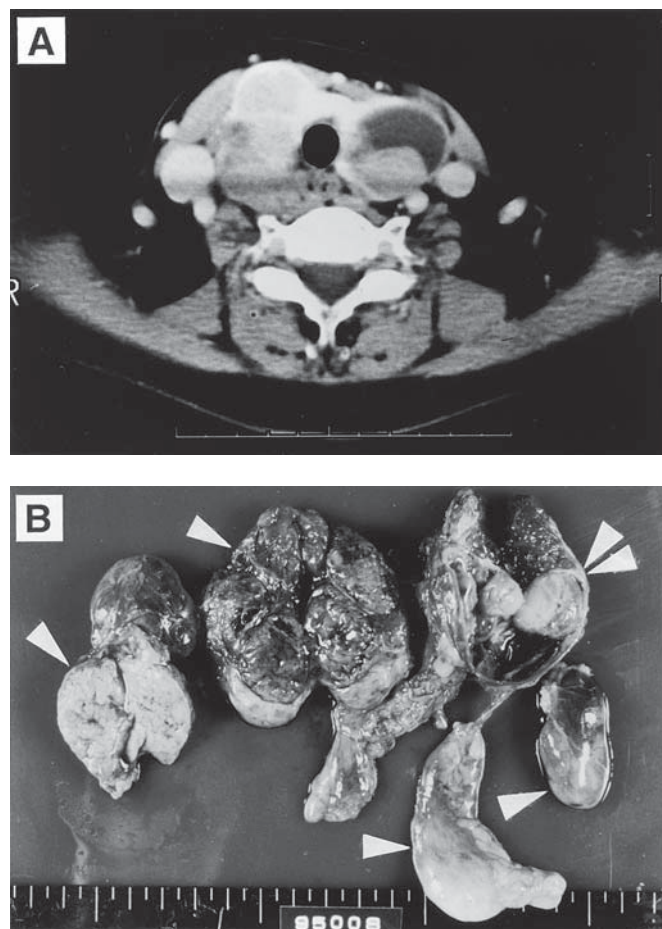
(A) CT scan of the neck demonstrating solid tumors in the right lobe and a cystic mass in the left lobe of the thyroid. (B) Cross-section of the resected large goiter showing markedly enlarged parathyroid glands (two sectioned tumors from the left and two unsectioned tumors from the right) and the thyroid gland with a cystic nodule (upper right). A single arrow indicates parathyroid tumor and double arrows indicate thyroid tumor.
